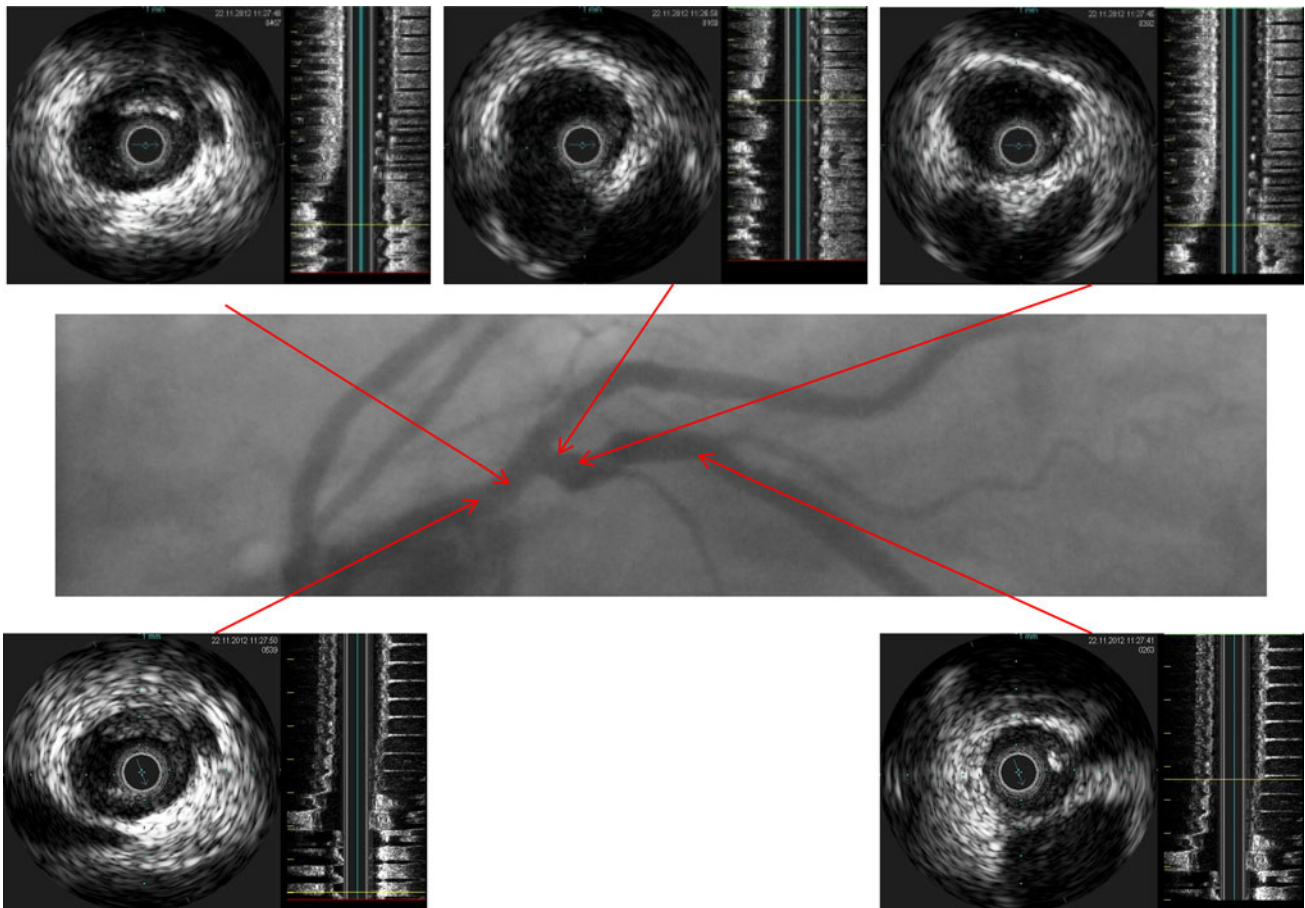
Images of intravascular ultrasound (IVUS) of the CX at different levels of the treated vessel. Vessel areas proximal and distal to the DCB-treated area with concentric atherosclerotic plaque burden. Reduced plaque burden in the DCB-treated area
